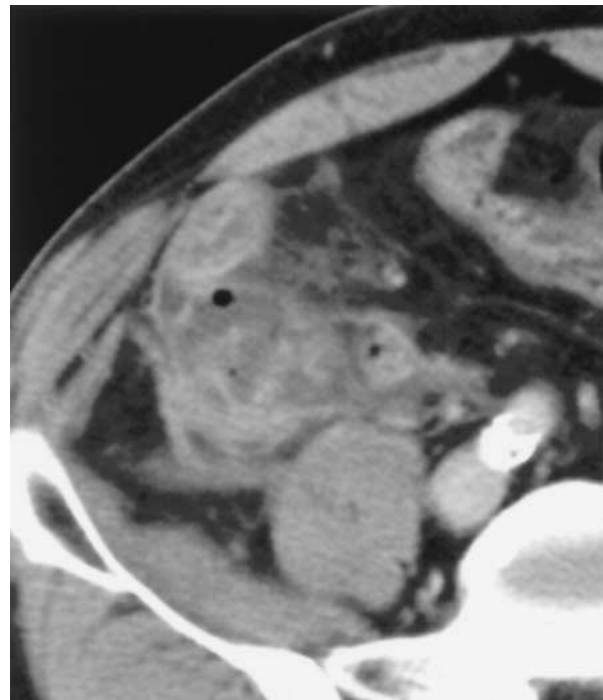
Contrast-enhanced CT image of perforated acute appendicitis. Phlegmon associated with gas bubbles is demonstrated at the periappendiceal region. The appendix itself is not visible.
